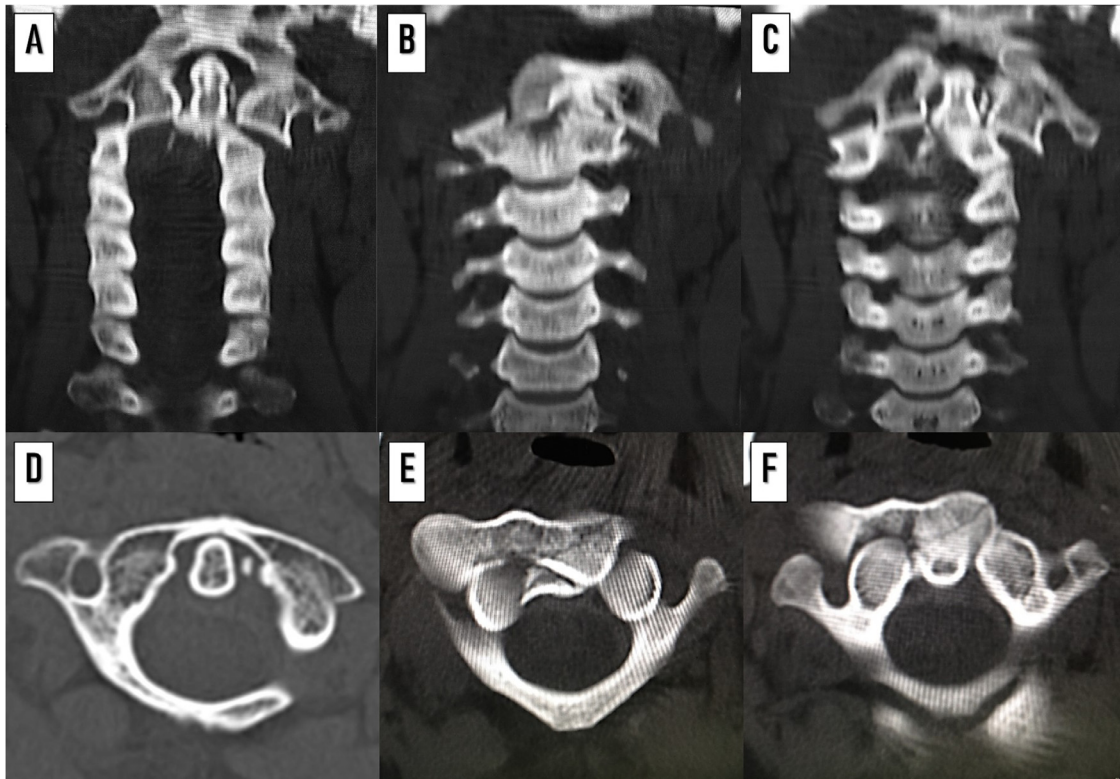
CT scan showing a left lateral atlanto-axial dislocation associated with a type II odontoid fracture with a laterally locked left lateral mass at the C1-C2 level in coronal (A-C), and axial (D-F) views.
